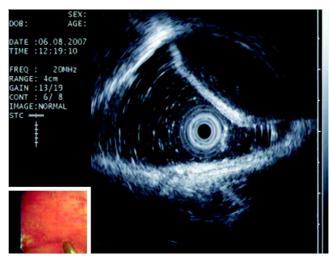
Endoscopic ultrasonography demonstrated a 4-cm well-circumscribed, hypoechoic, homogeneous lesion compressing the cecal wall.
